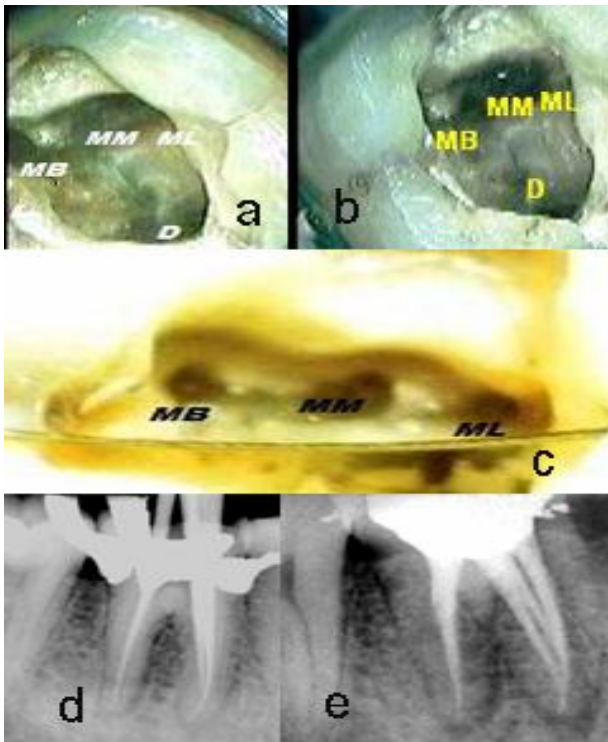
(a, b) occlusal view of the pulp chamber floor with the orifice of the (MB, mesiobuccal; MM, middle mesial; ML, mesiolingual; D, distal). (c) Orifice location of middle mesial (MM). (d) Gutta cone fit. (e) Postoperative radiograph.
